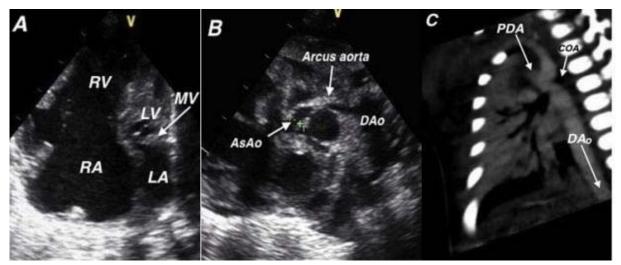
1A, 1B; Echocardiogram showing hypoplastic left heart, aortic valve atresia, hypoplastic ascendens aorta, ductus dependent systemic circulation and large atrial septal defect, 1C; Cardiac computerize tomography angiography not observing left ventricul exit, ascending aorta and arcus aorta.
